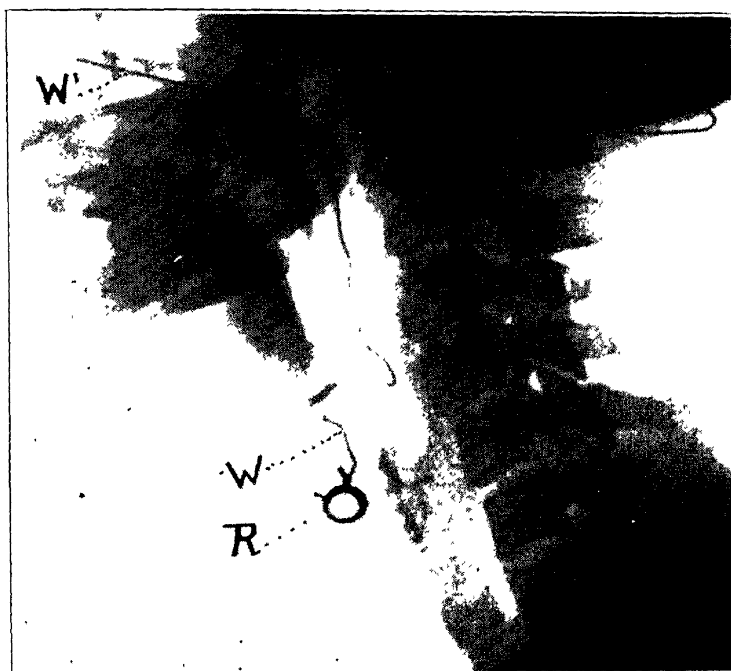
Lateral roentgenogram showing spring ring anchored in laryngeal web. R indicates the ring;  $WW'$ , the wire. (Iglauer: Arch. Otolaryng.)
